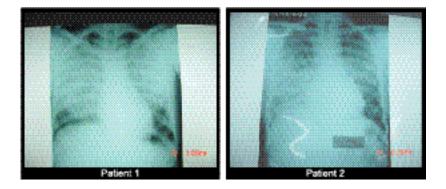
Radiographs from two paients with Nipah encephalitis
